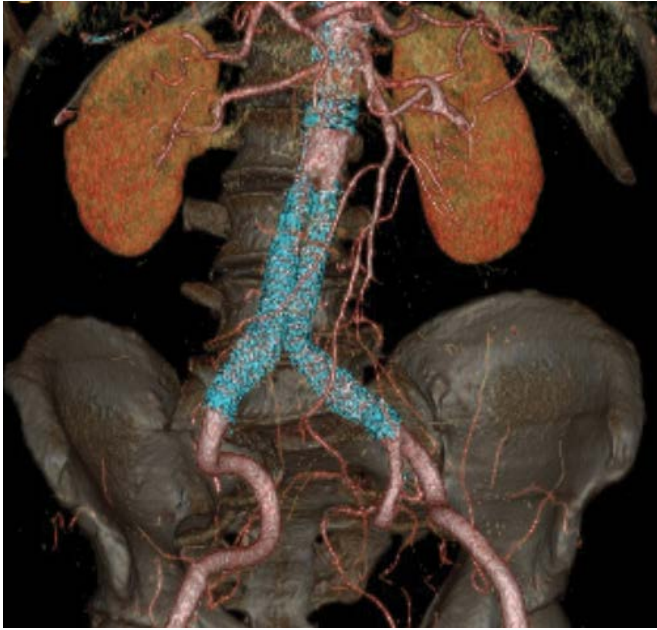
CTA and reverse MIP demonstrated an Ovation abdominal stent graft endoprosthesis, appropriately placed in the infrarenal aortoiliac anatomy demonstrating the final result and radiological success.
